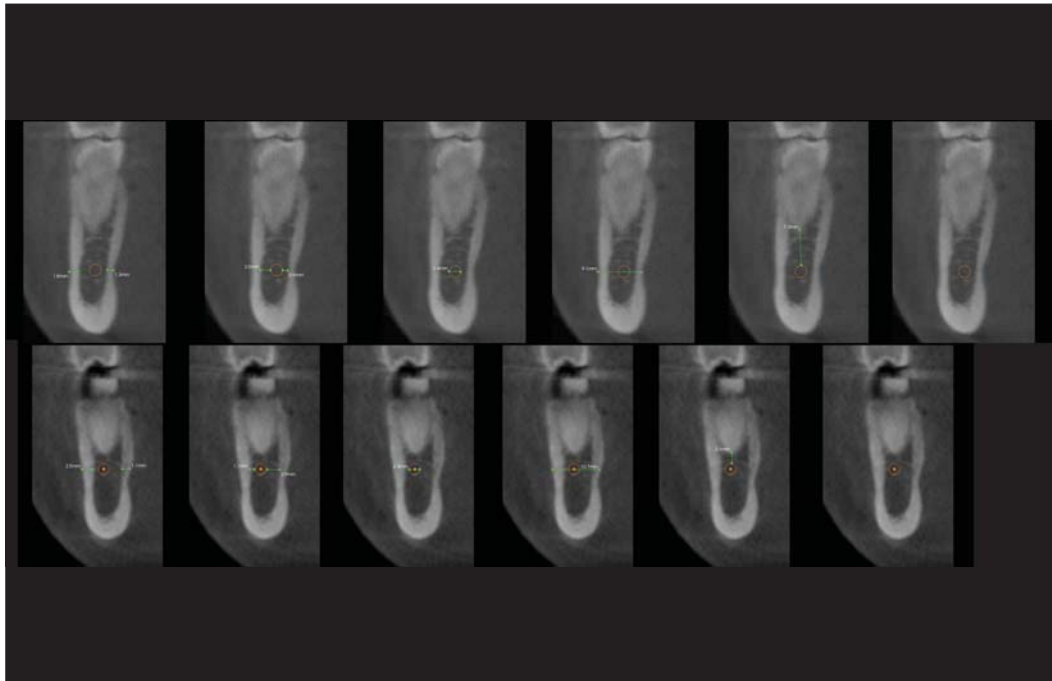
CBCT image showing the dimension and position of Inferior Alveolar Nerve Canal in 36 and 46. Upper row the left side mandibular molar and bottom row the second molar in the same region
